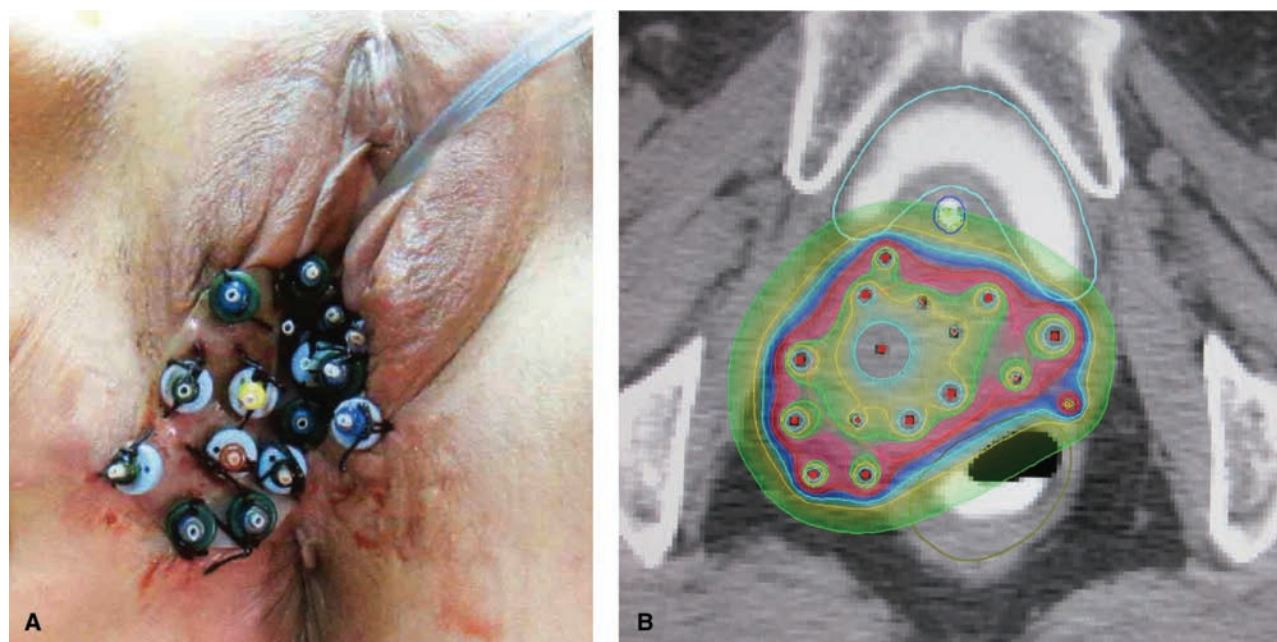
A and B: High-dose-rate interstitial brachytherapy for vaginal stump recurrence. A: External view of the application. Vinyl template applicators are used in this case. B: Dose distribution curves superimposed on a relevant CT image. Red line: 100% prescribed isodose line. Orange line: CTV (Special courtesy of Dr. K. Yoshida, Department of Radiology, Osaka National Hospital).
